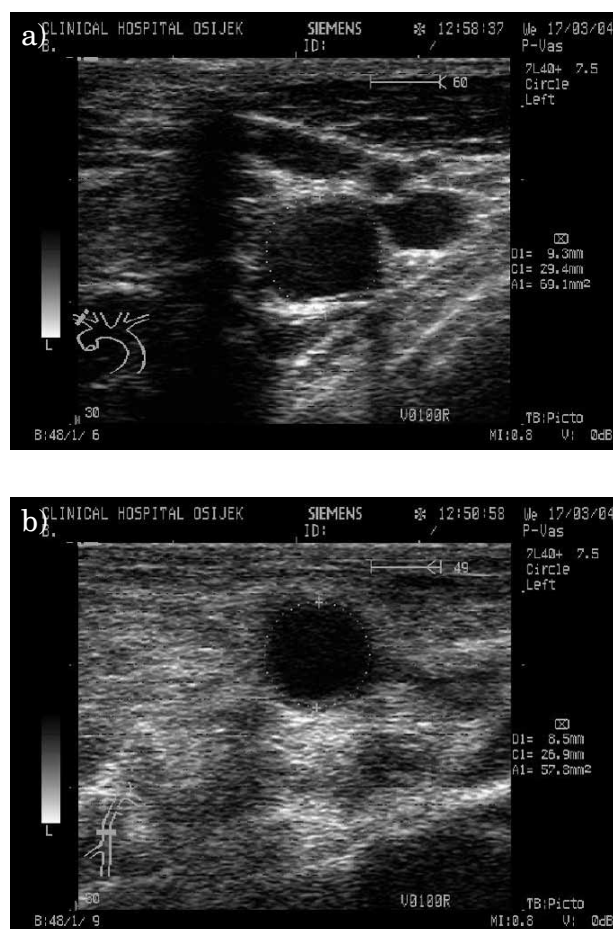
a) Measurement of diameter of subclavian artery by Color Doppler ultrasound; b) Measurement of diameter of iliac (femoral) artery by Color Doppler ultrasound.
